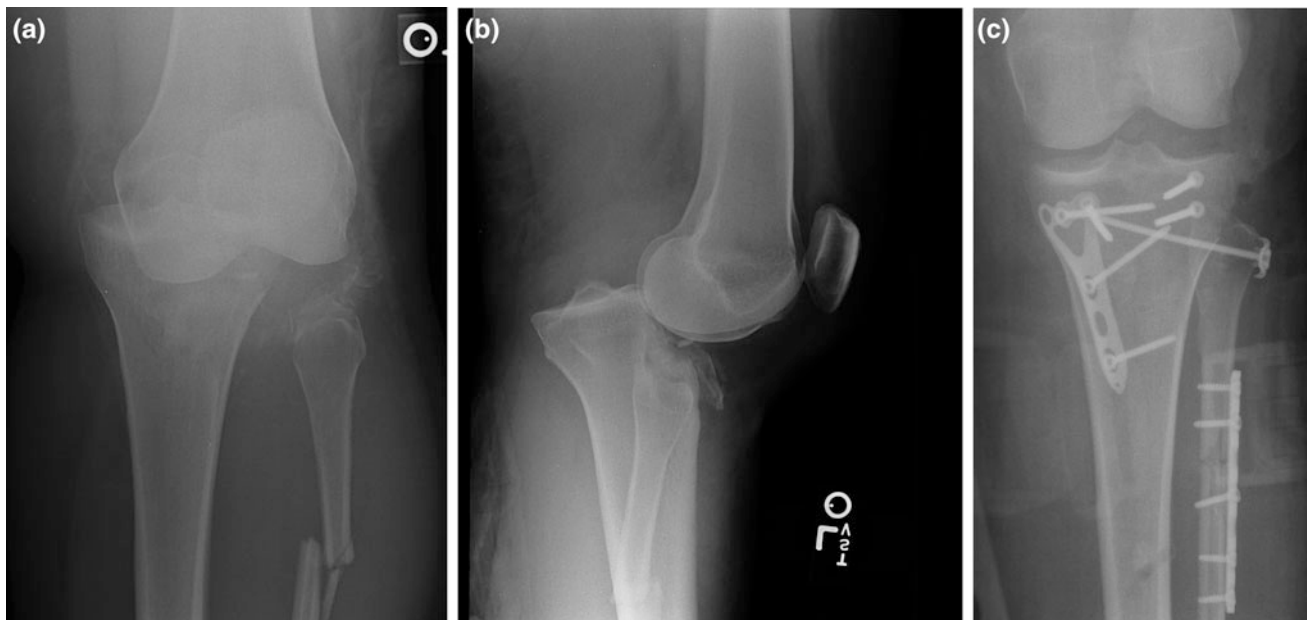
a Anteroposterior (AP) and b lateral radiographs of open tibial plateau, proximal tibiofibular joint dislocation, and fibular neck fracture that required multiple debridements. c Open reduction and internal fixation (ORIF)
